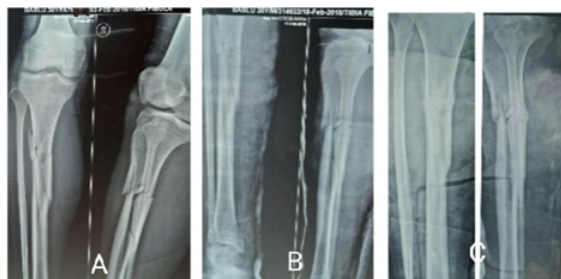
30 yrs old male patient (A) initial x-ray (B) at 4 wks (C) at 16 wks
